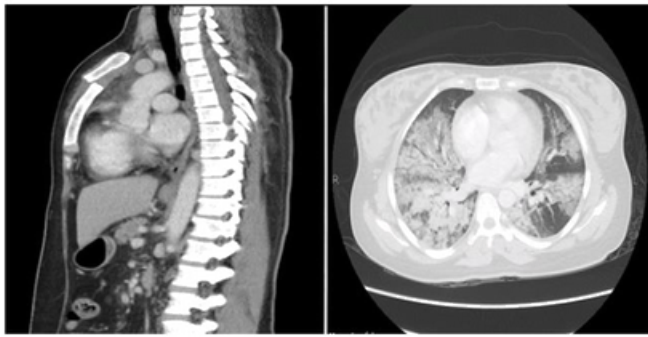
(Left) Sagittal view of CT scan showing manubriosternal dislocation. (Right) Lung window of CT scan showing pulmonary contusions more marked on Right
